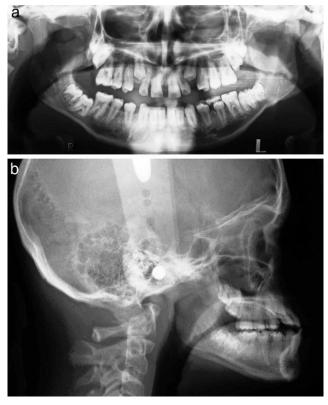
Radiographs of a subject with Down syndrome without any permanent tooth agenesis.
